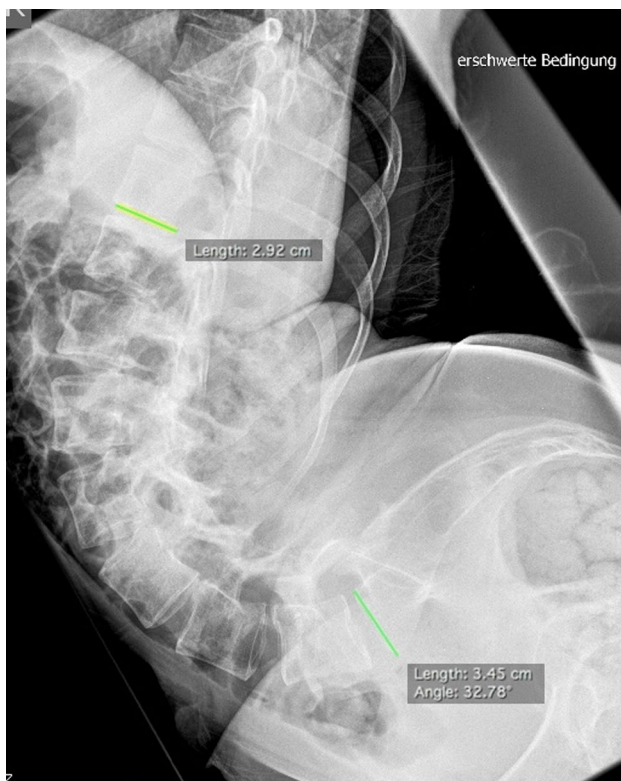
Lateral radiograph of the lumbar spine acquired in a supine position 6 months prior to the presentation. At this point, the lordosis angle measured only 150°
